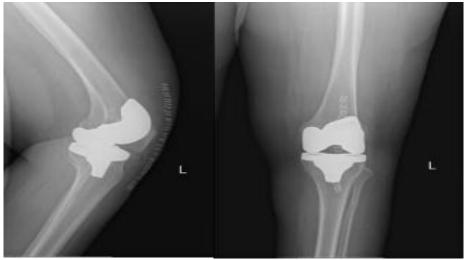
Postoperative left knee X-rays.
